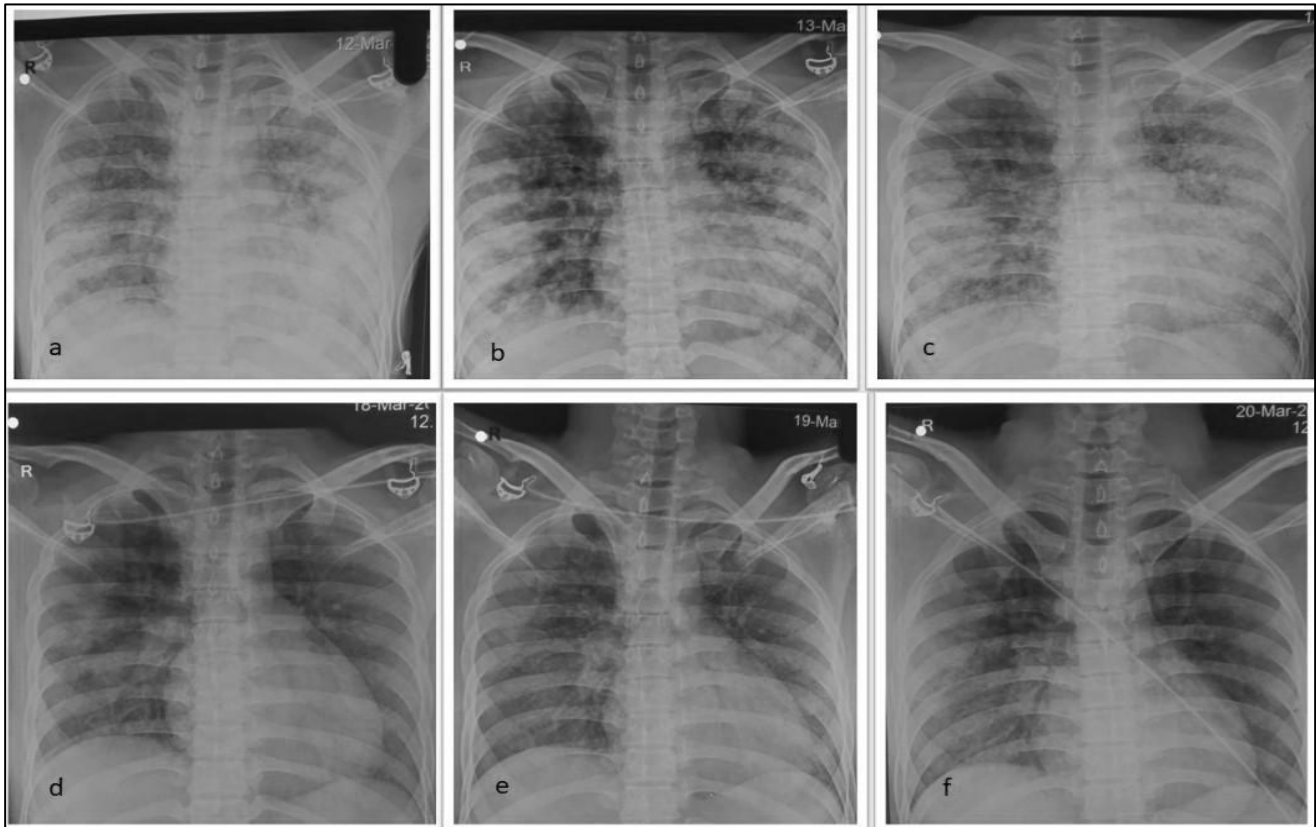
Serial chest radiographs taken in the ICU. (a-c) Progressive bilateral diffuse alveolar infiltrates in the immediate postoperative period, consistent with acute lung injury/ FES. (d-f) Gradual radiographic resolution over subsequent days with supportive management.
